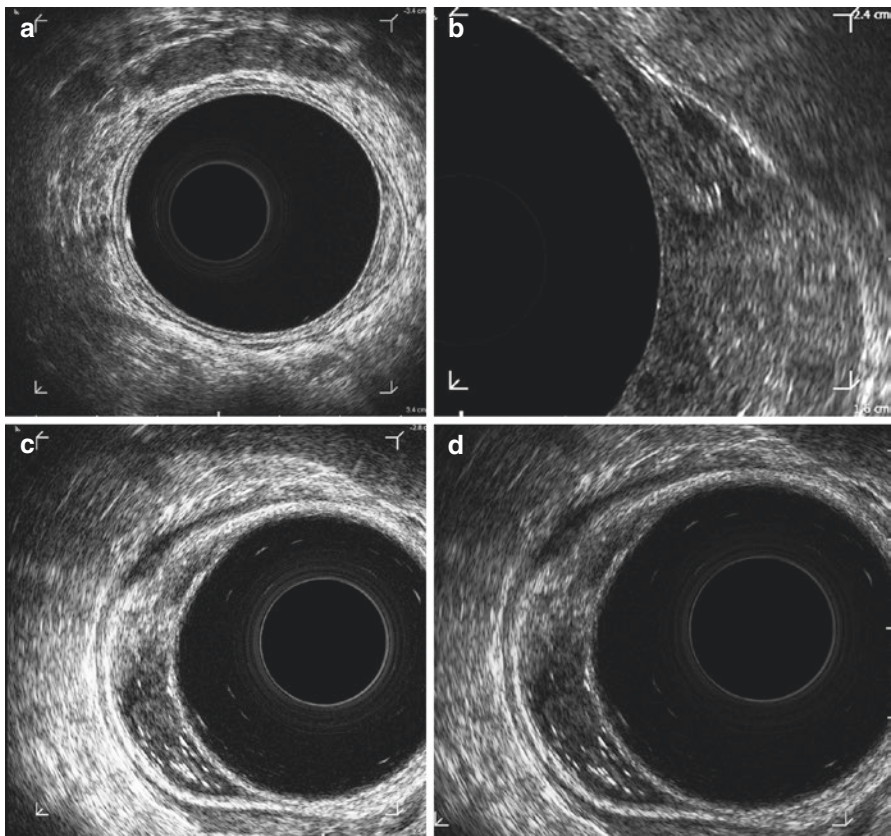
(a–d) Endorectal ultrasound in rectal cancer staging. The sonographic 5-layer structure of the rectal wall consists of 3 hyperechoic layers (interface between the balloon and mucosa, submucosa, and perirectal fat/serosa) separated by 2 hypoechoic layers (muscularis mucosa and muscularis propria). Lesions are T staged as uT0/uTis when the mass is within the hypoechoic M. mucosa layer, as uT1 when invading the hyperechoic submucosal layer, and as uT2 if they cause a distinct break in the submucosal layer and invade into the hypoechoic muscularis propria layer. (All images used with permission of Springer Nature from Valinluck Lao and Fichera [53].)
